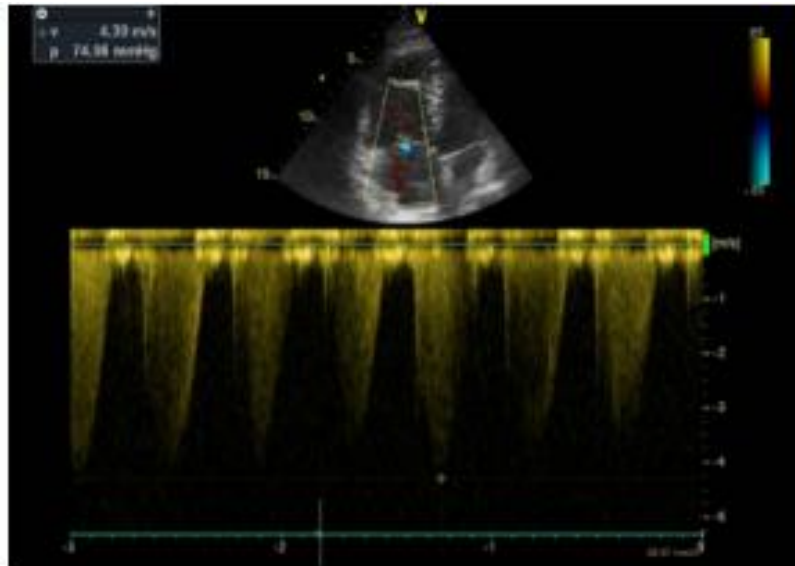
Transthoracic cardiac ultrasound increased systolic pressure in the pulmonary artery - 74 mmHg
